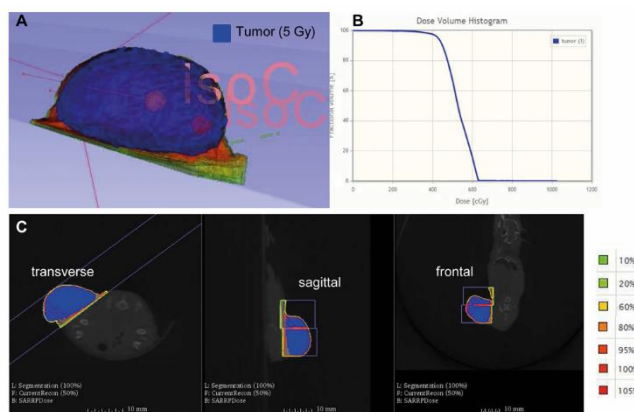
Irradiation was performed using SARRP. Upon radiation with 2 or 5 Gy, a CT was done allowing to mark and define the tumor (blue) (A). CTs are shown in transversal, sagittal and frontal orientation (C). Isocenters were set to locate the beams and to calculate the dose distribution within the tumor (A, B). One representative image is shown from a subcutaneous HuH7 xenograft tumor irradiated with 5 Gy.
